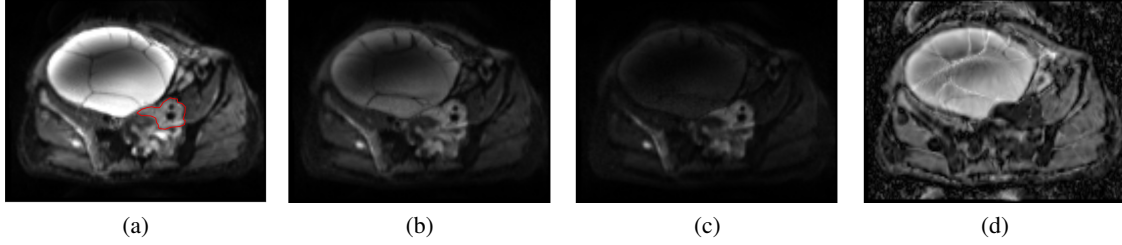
An axial slice of the DWI volume acquired with b-values (a) 50, (b) 400, (c) 800 s/mm^2 . The estimated ADC map is shown in (d). The red contour in image (a) denotes the tumor boundary.
